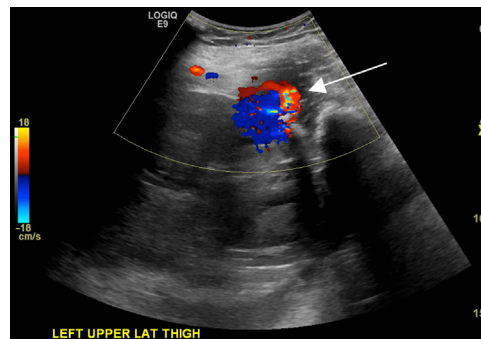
Color Doppler image of the left lateral thigh demonstrates a pseudoaneurysm (arrow) with classic Yin-Yang configuration. (Color version of figure is available online.)
